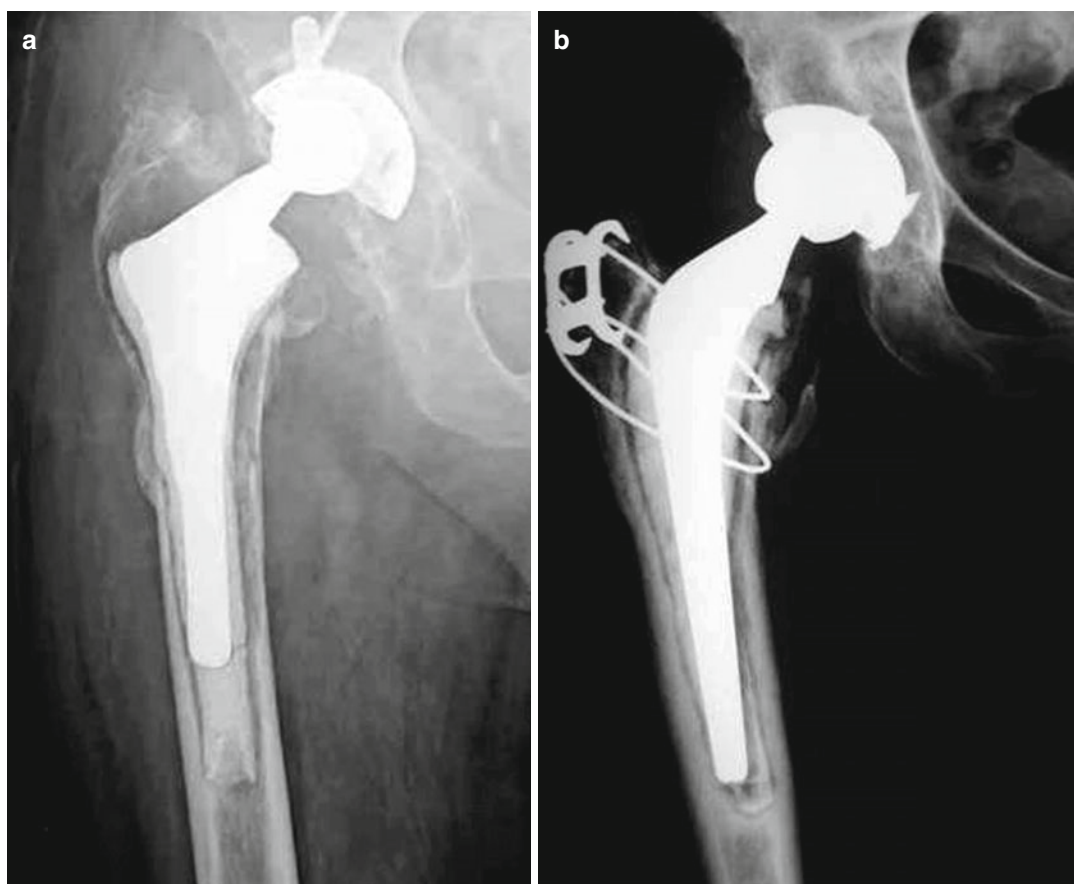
Hip implant complications. Aseptic loosening: right hip radiography (a). Septic loosening: right hip radiography (b), ultrasound study of a flogistic collection
